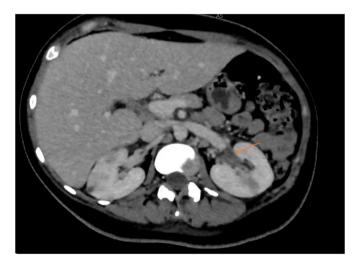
Axial CT-scan view showing a left lower segmental renal vein thrombosis (orange arrow). (For interpretation of the references to colour in this figure legend, the reader is referred to the Web version of this article.)
